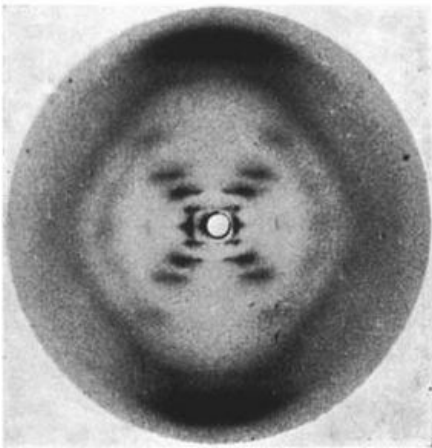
The “photo 51” closeup x-ray image of DNA produced by Raymond Gosling and Rosalind Franklin. Courtesy of bbc.co.uk.
